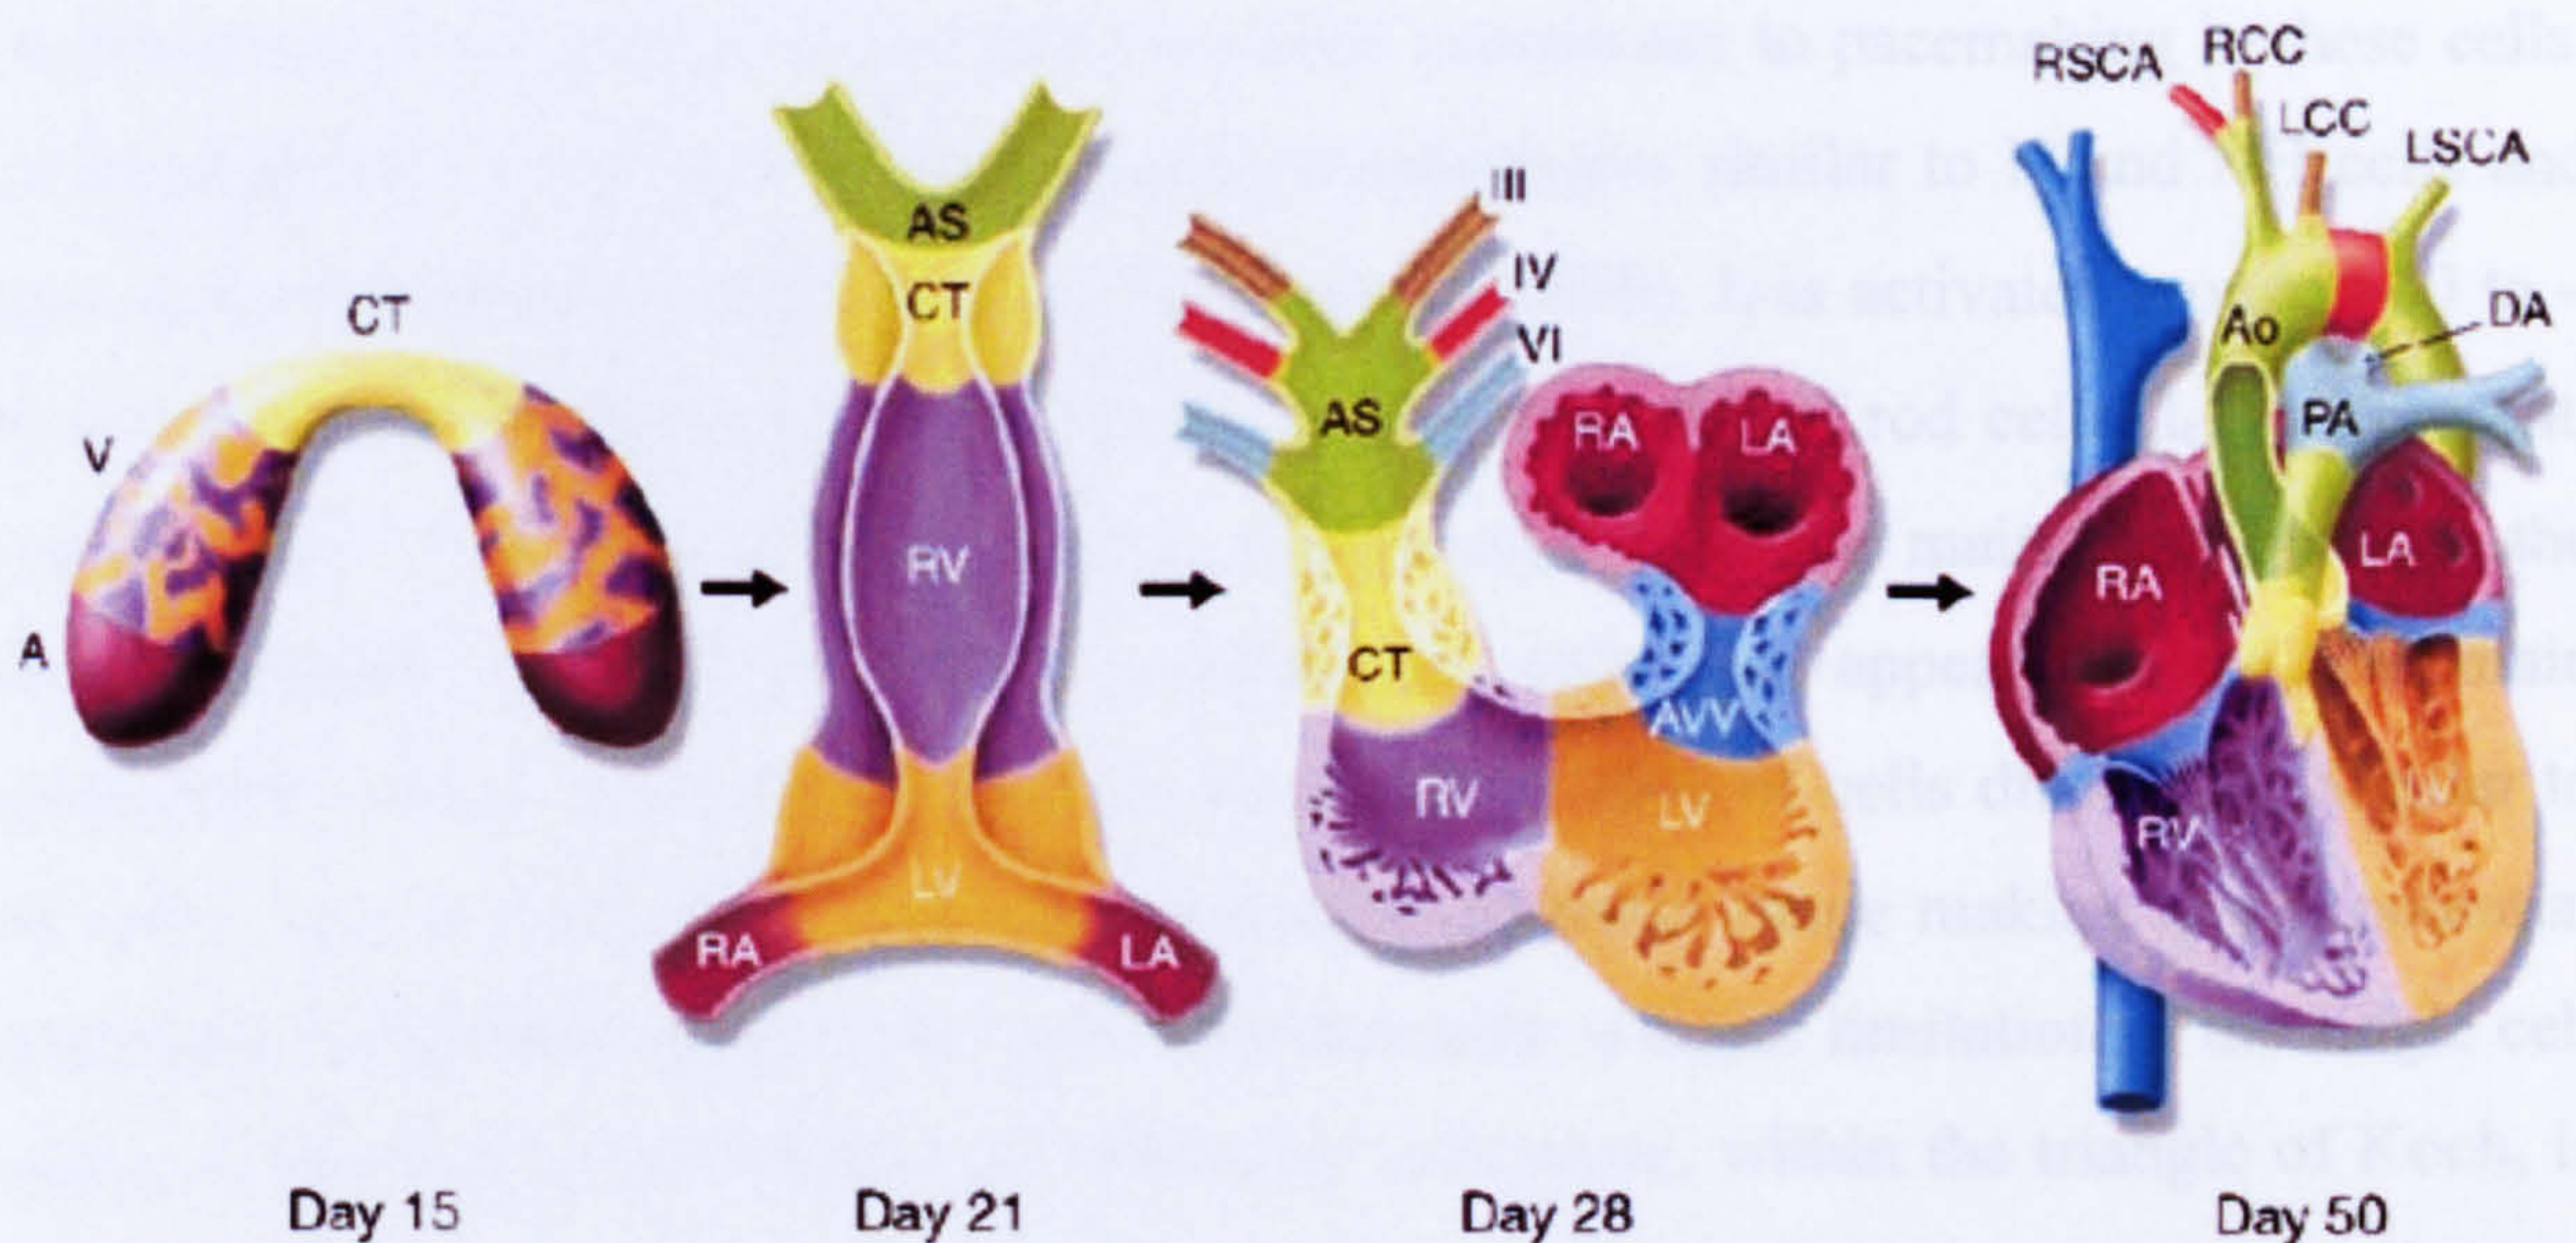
Cardiac development from the cardiac crescent. Cardiogenic precursors form a crescent (day 15) that is arranged to form specific segments of the linear heart tube. Each cardiac chamber develops from the outer curvature of the looped heart tube. Neural crest cells are predominantly located in the aortic arch arteries (III, IV and VI) and the aortic sac (AS). Mesenchymal cells form the cardiac valves from the conotruncal (CT) and atrioventricular valve (AVV) segments. A, atrium; Ao, aorta; DA, ductus arteriosus; LA, left atrium; LCC, left common carotid; LSCA, left subclavian artery; LV, left ventricle; PA, pulmonary artery; RA, right atrium; RCC, right common carotid; RSCA, right subclavian artery; RV, right ventricle; V, ventricle. From Srivastava and Olson, (2000).
